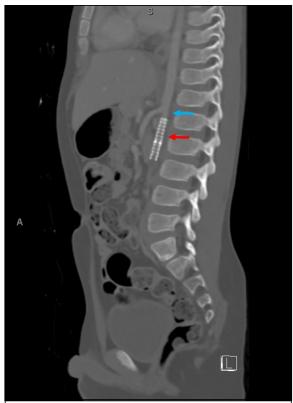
Abdominal CT Angiography (sagittal plane) showing contrast in the descending aorta (blue arrow), and absence of flow through the aortic stent (red arrow).
